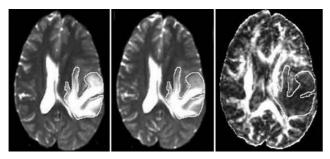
(A–C)Resolution of peritumoral edema (diffusion tensor magnetic resonance imaging [DT-MRI]) with dexamethasone treatment. (A) Before steroid therapy. (B) 24 hours after steroid therapy. (C) 72 hours after steroid therapy.
